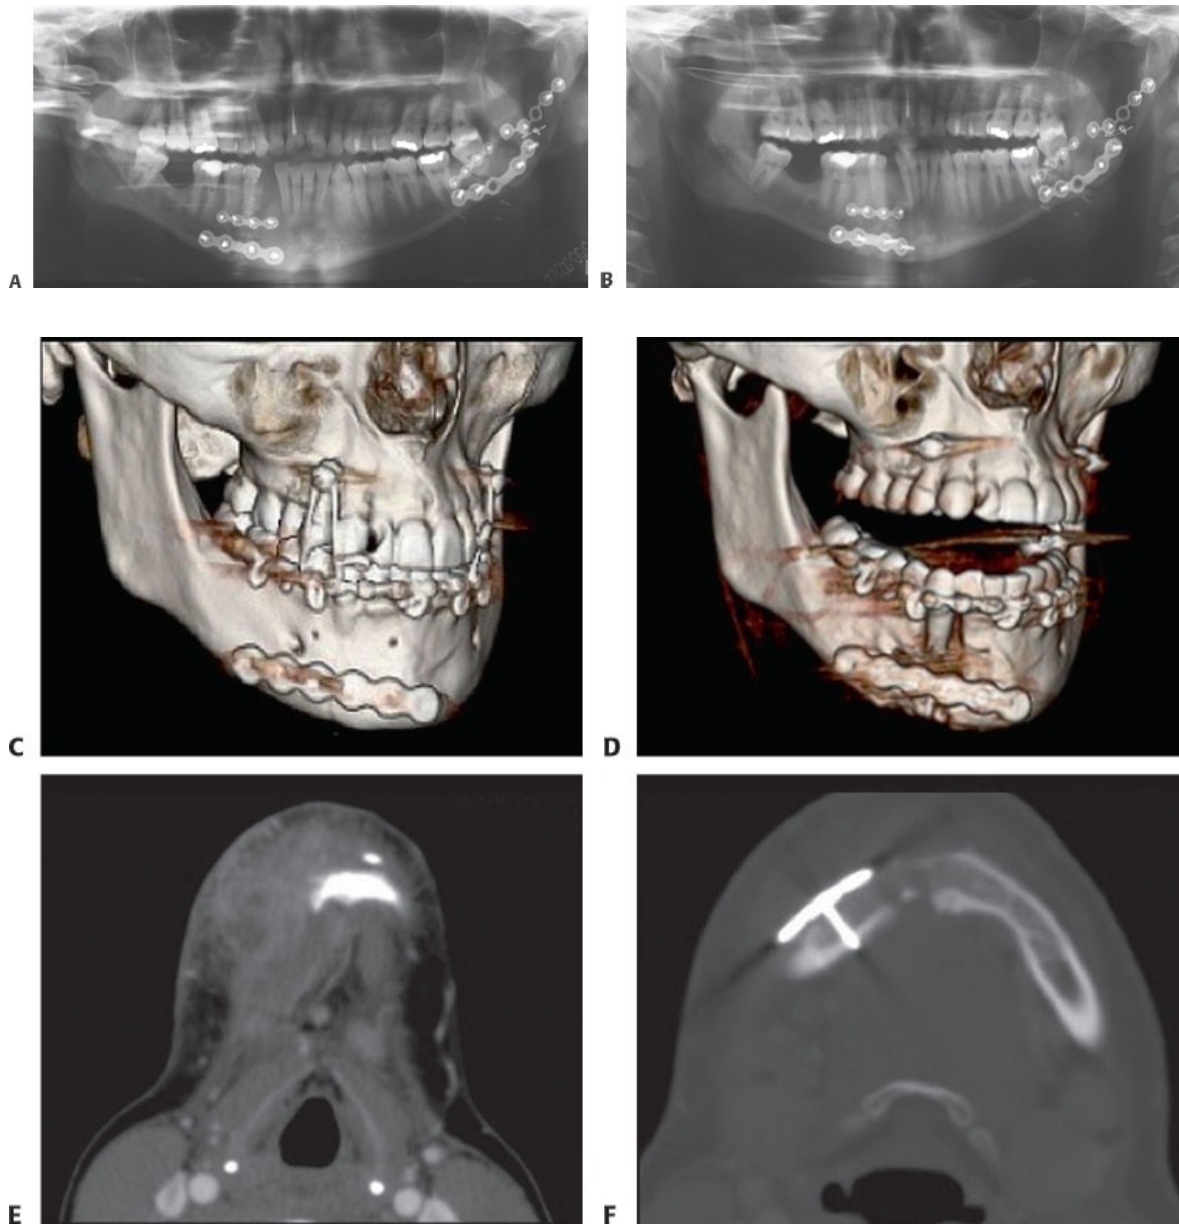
• A. Immediate postoperative panoramic plain radiograph after ORIF of multiple mandible fractures. B. Follow-up panorex demonstrating hardware loosening and nonunion of the left mandibular angle fracture. C. A 3D reconstruction of CT images demonstrating right parasymphyseal fracture immediately after open reduction and internal fixation. D. Repeat CT imaging showing evidence of nonunion at 4 weeks after surgery. E. Soft tissue window revealing evidence of abscess
